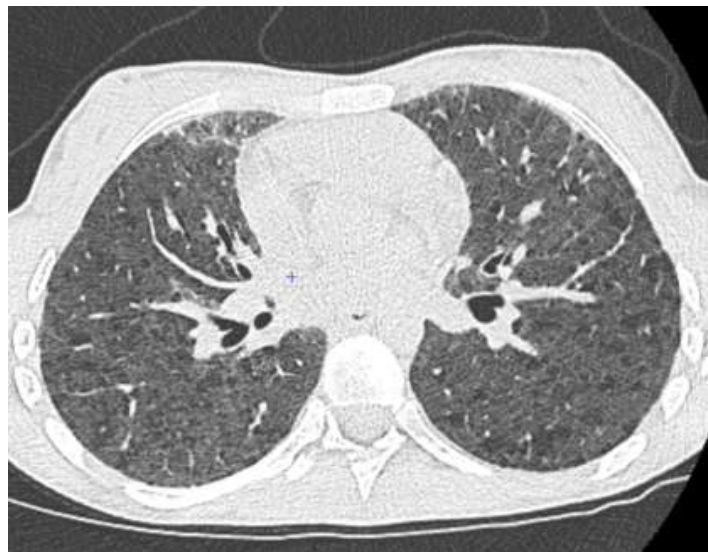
Axial high-resolution chest CT scan showing multiple bilateral thin-walled pulmonary cysts diffusely distributed throughout the lung parenchyma, suggestive of lymphangioliomyomatosis
